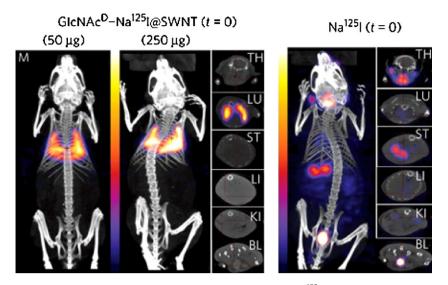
Whole-body SPECT/CT carried out immediately after tail-vein injection of glycosylated Na¹²⁵I carbon nanotubes compared to injection of Na¹²⁵I. These functionalised carbon nanotubes show remarkably specific lung accumulation. Reprinted by permission from Macmillan Publishers Ltd: [Nature Materials 2010;9(6):485–90], copyright 2010.
